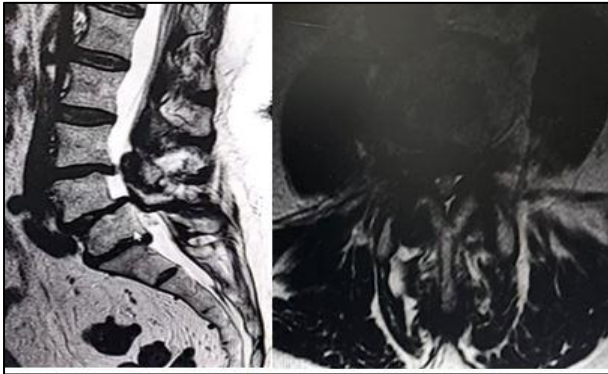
Pre-operative MRI- L3-L5 lumbar spinal stenosis.
